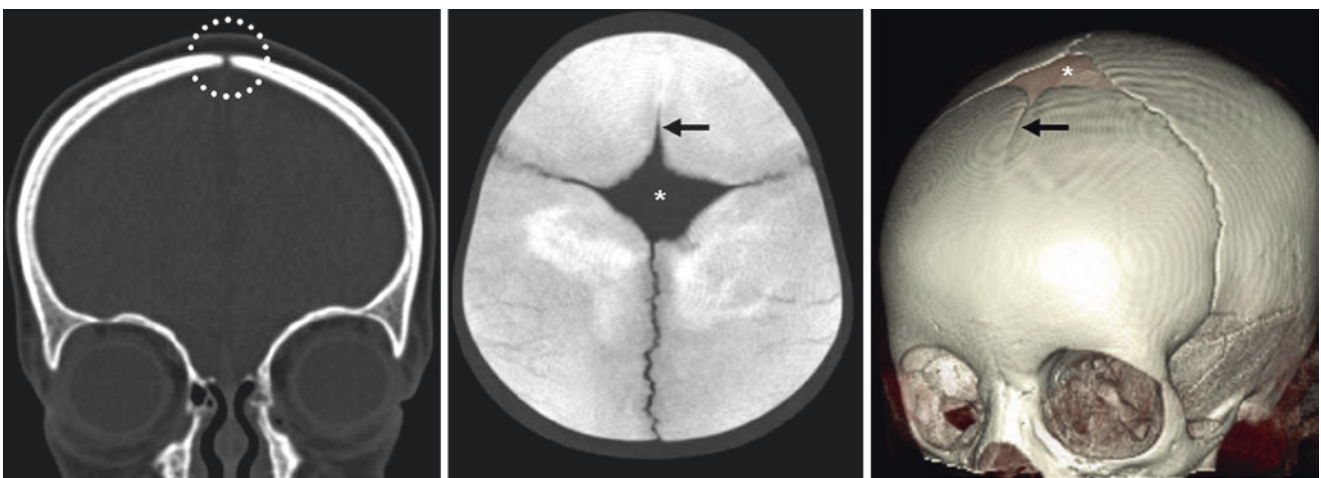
An 11 month old with a partially fused MS (black arrows and dashed circle) on an 0.7-mm coronal MPR (left), axial 20-mm MPR (middle), and a 3D VR CT (right, left anterior oblique [LAO] view). There is an entirely patent AF (asterisks)
